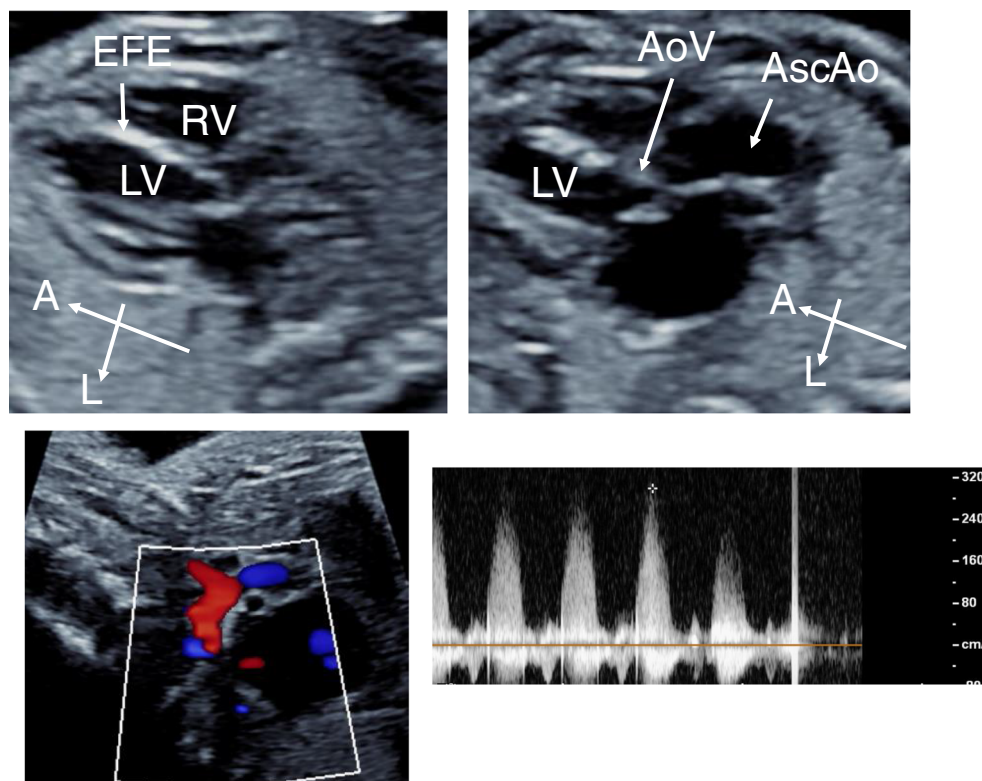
Characteristic findings in severe fetal aortic stenosis. Panel a, 4-chamber view showing normal-sized left ventricle with evidence of endocardial fibroelastosis involving the ventricular septum. Panel b, thickened aortic valve leaflets and dilated ascending aorta. Panel c, retrograde flow in the aortic arch. Panel d, Doppler velocity measured across the aortic valve showing elevated flow velocity at ~ 3 m/s. RV, right ventricle; LV, left ventricle; EFE, endocardial fibroelastosis; A, anterior; L, left; Aov, aortic valve; Asc Ao, ascending aorta.
